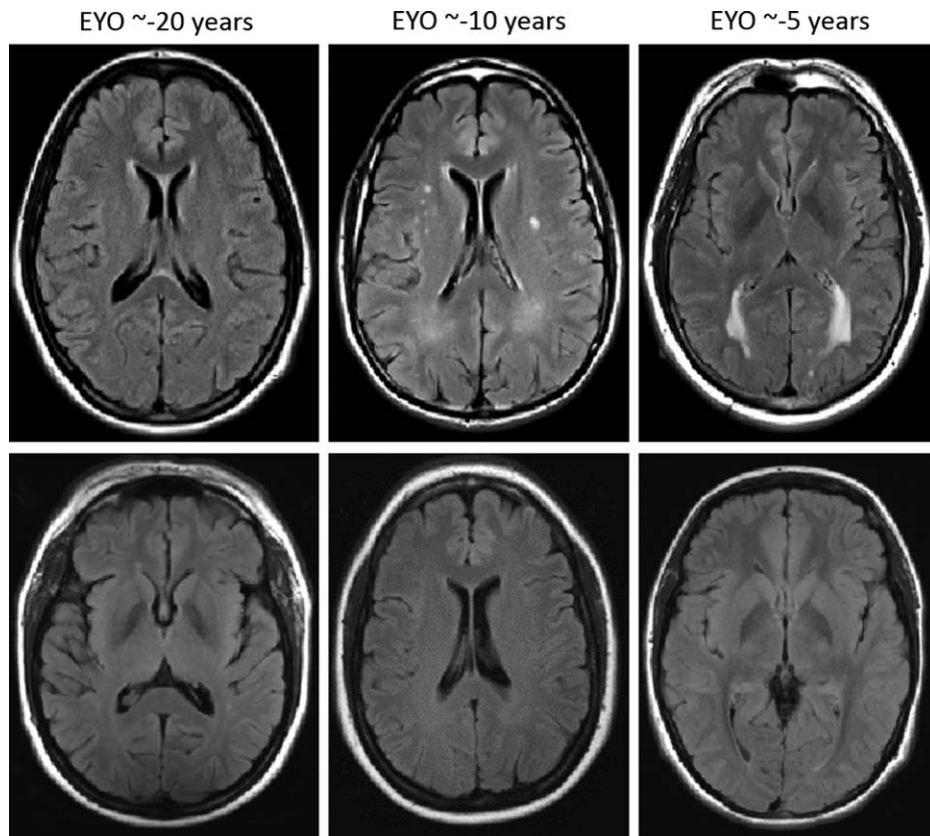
Examples of WMH distribution in mutation carriers (upper row) and noncarriers (lower row) across three EYO time points. Top row displays examples of T2-weighted FLAIR MRI scans from 3 mutation carriers at varying estimated years from symptom onset (based on parental age of onset). Bottom row displays examples of MRI scans from noncarriers matched for estimated years from symptom onset (based on parental age of onset). All participants displayed in this figure had CDR scores of 0 at the time of MRI scan. CDR = Clinical Dementia Rating scale; EYO = estimated years to symptom onset; FLAIR = fluid-attenuated inversion recovery; MRI = magnetic resonance imaging; WMH = white matter hyperintensity.
